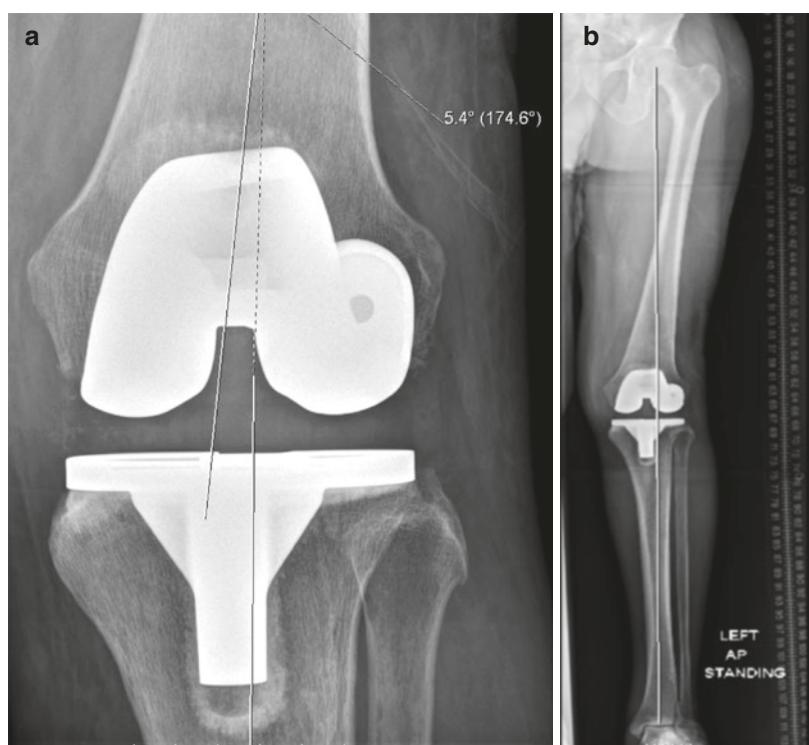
Postoperative radiographs demonstrating well-aligned components
